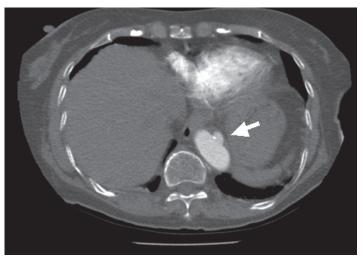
Computed tomography image depicting the lesion in the descending aorta.
